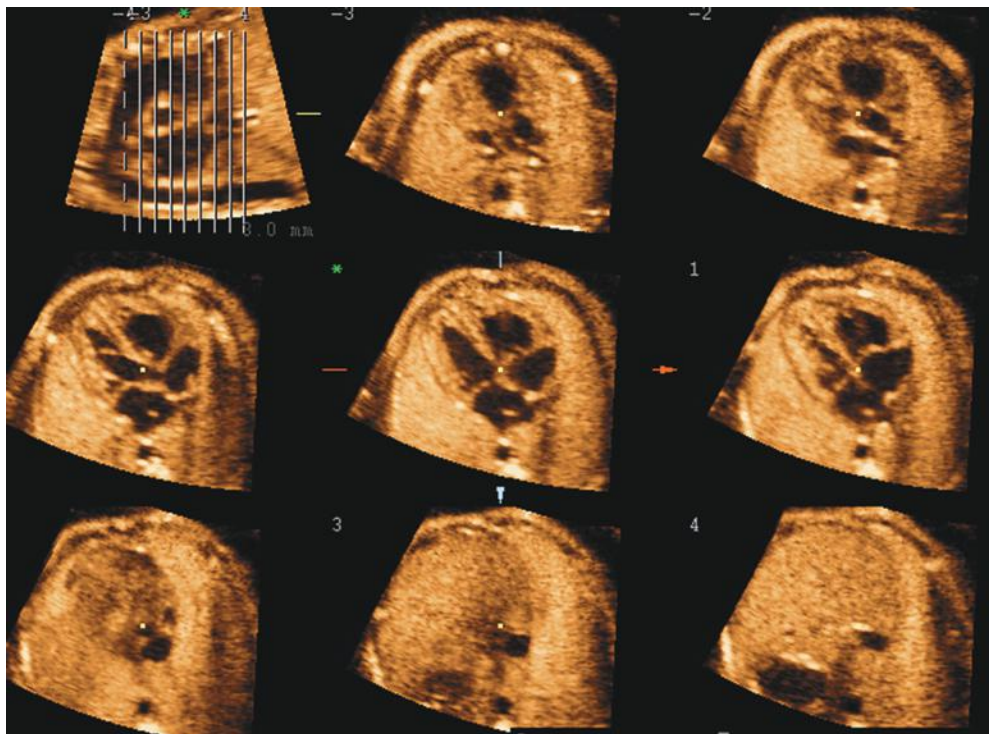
Tomographic ultrasound imaging: an overview image is shown in the upper left corner; the parallel lines in the overview image demarcate the position of the slices within the volume dataset.
